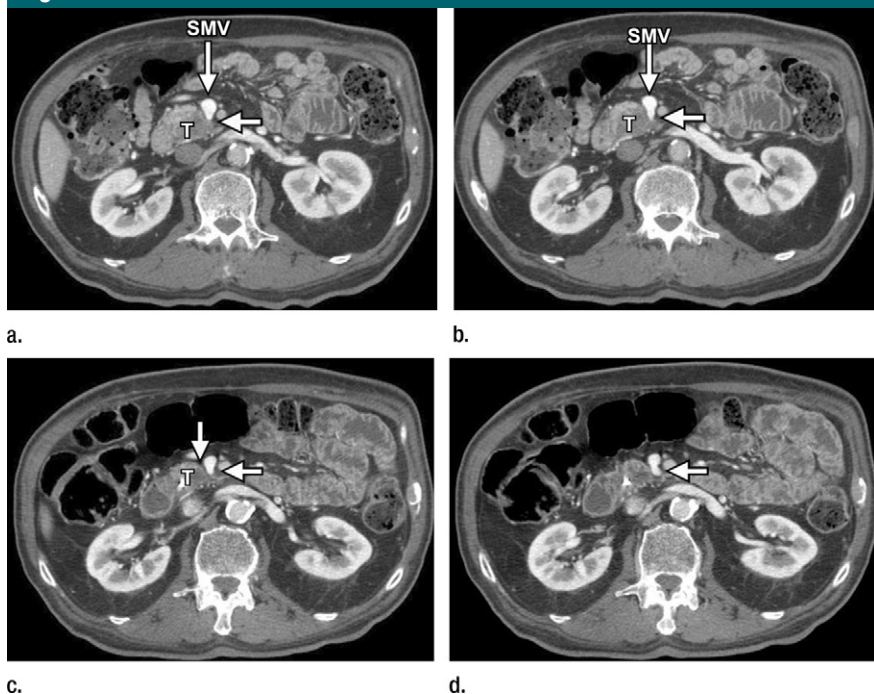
Images in a 68-year-old woman with pancreatic head mass and perivascular increased haziness or stranding. (a, b) Axial contrast-enhanced biphasic multidetector CT angiogram shows a mass in the pancreatic head (T). Tumor contacts less than 180° of the SMV circumference and there is extension to the first draining vein (short arrow). The tumor involvement of the SMV and draining vein places the patient in the unresectable category. (c, d) Following chemotherapy and radiation therapy, there is shrinkage of the tumor and replacement of the solid tumor contact with the SMV and the draining branch by increased haziness, likely representing fibrosis rather than tumor (short arrows). The tumor was resected with negative margins.
